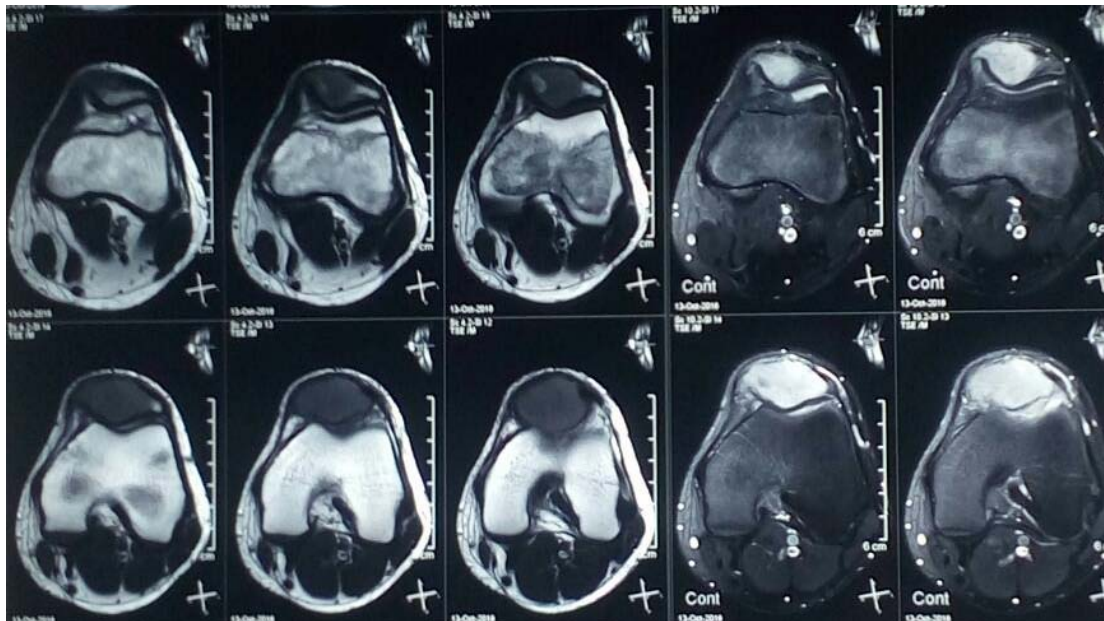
Axial T1 and T2 MRI show defect in anteroinferior aspect of patella
